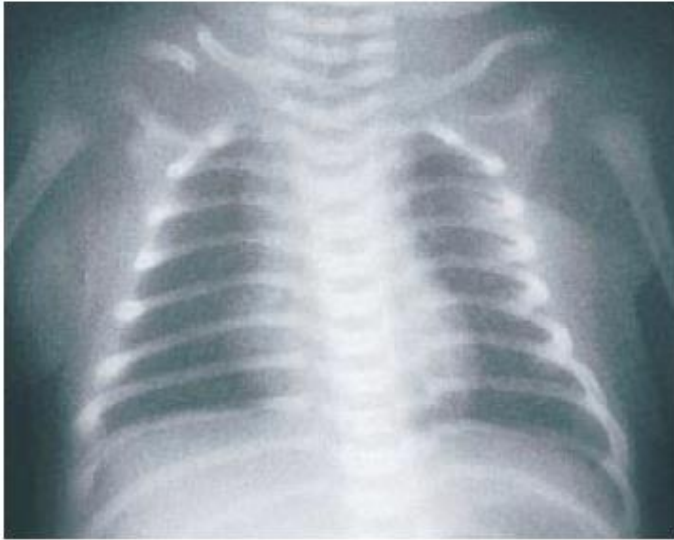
A radiograph of the chest showing a fracture of the right clavicle. The clavicle is the site of the most common fracture during delivery especially if shoulder dystocia is present. Healing is rapid because of the speed with which callus formation occurs and it is rare to have any permanent deformity.
